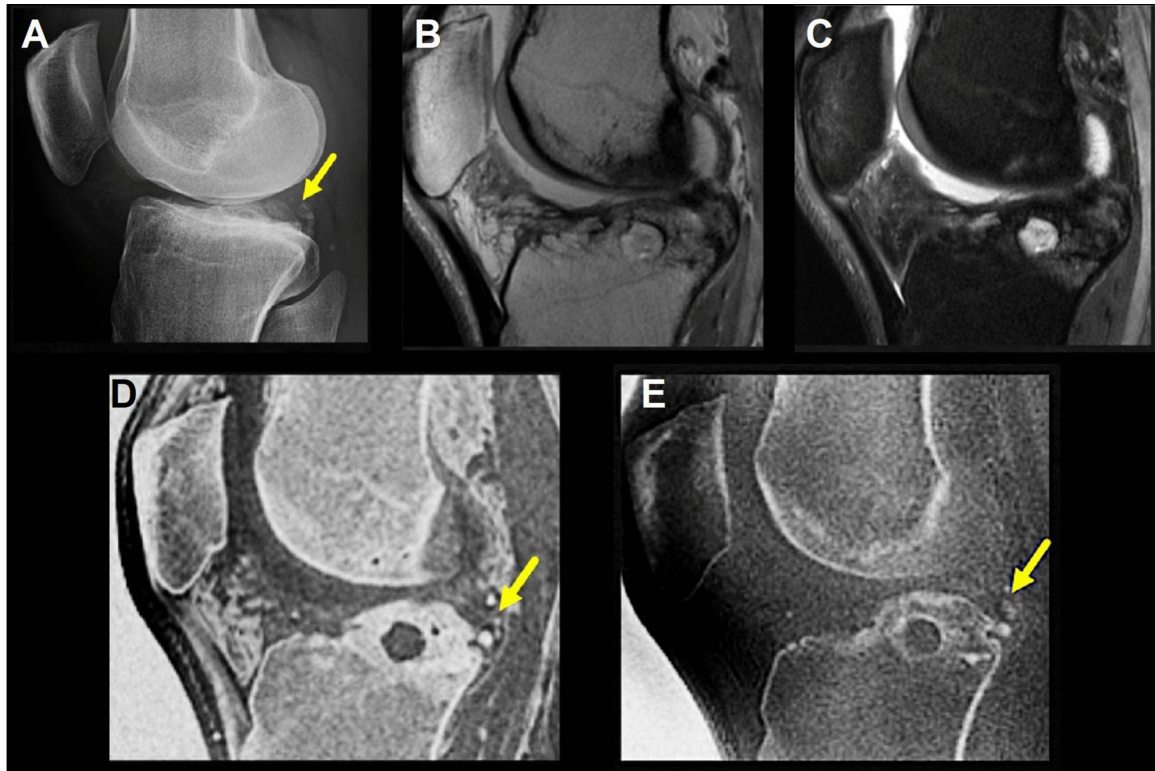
25-year-old man presented with left knee pain post-lateral meniscus transplant surgery. Radiograph (A), PD-weighted (B), IwFS-weighted (C), SPGR (D), and ZTE (E) sequences. While the posterior tibial calcification and osteochondral bodies (arrows) are well-characterized on the ZTE as well as SPGR sequences, they are not visualized on the PD and IwFS sequences. The radiograph shows multiple osseous densities (arrow in A), confirming the findings noted on ZTE and SPGR to be intra-articular bodies, ruling out image artifacts
